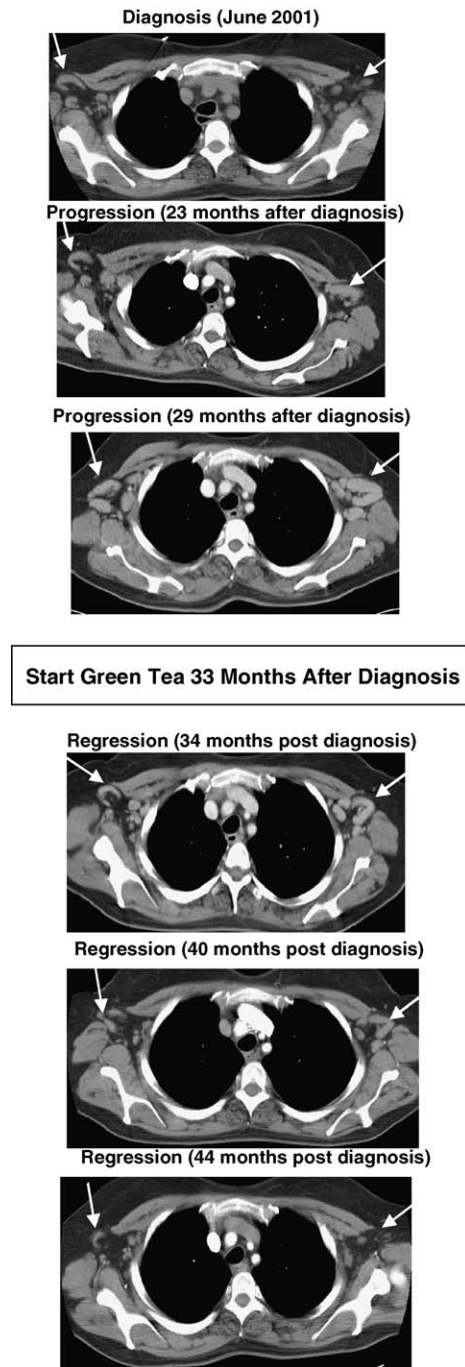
Fifty-eight-year-old woman with CLL/SLL: serial CT scans prior to and after initiation of green tea containing products.
